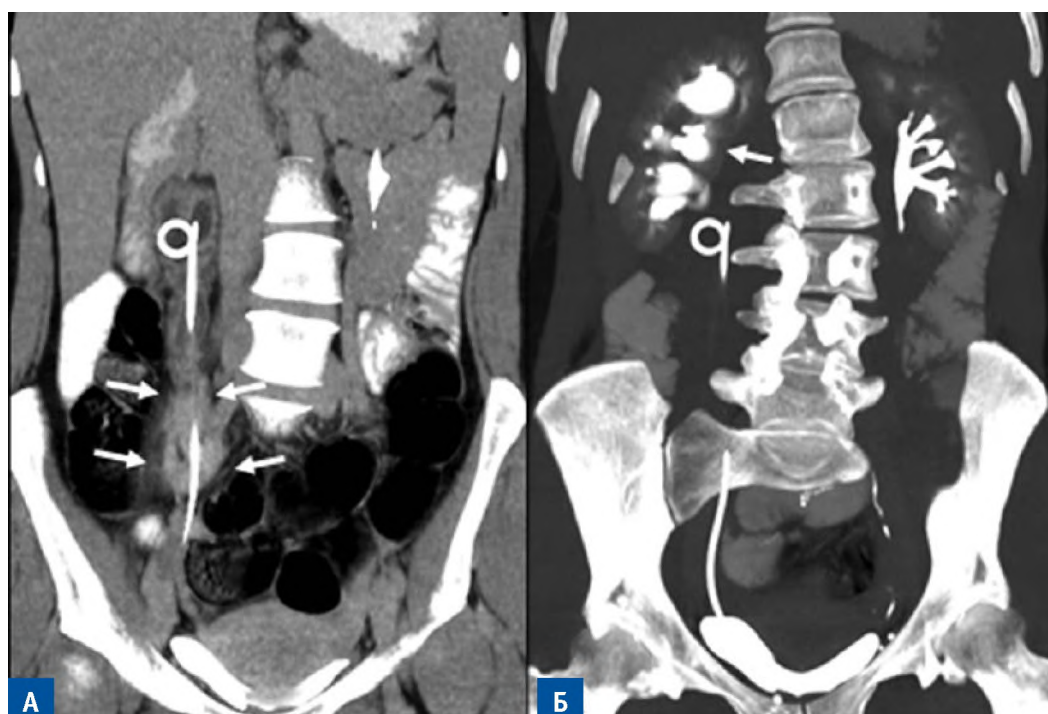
CT with intravenous contrasting, patient Ch, 36 years old. A — coronal projection; infiltrative growth of DF (arrows) involving the right ureter with a stent placed inside; Б — MIP-reconstruction; hydronephrotic transformation of the pyelocaliceal system of the right kidney (arrow)
